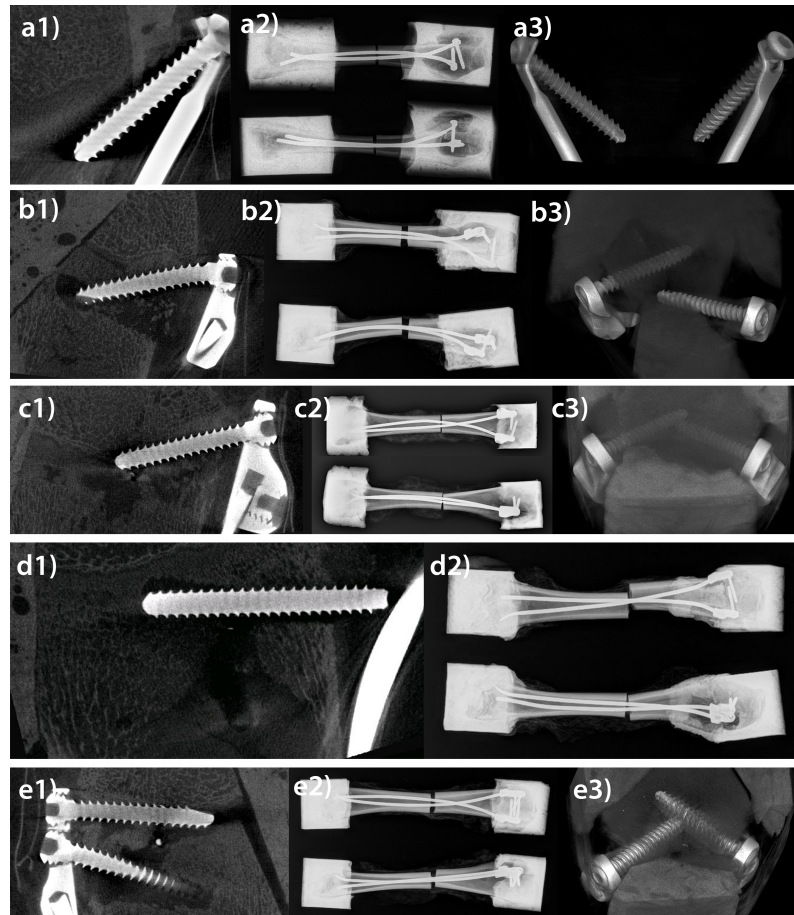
Used interlocking systems Ender nail a), Plug 3.5 b), Fixplug c), Plug 3 d) and Twin plug e) are displayed within this figure.  $\mu$ CT coronal views are displayed in a-e 1), a-e 2) show clinical radiographs, performed at the Department of Paediatric Radiology, Medical University of Graz, a-c 3) and e3) show 3D reconstructions of  $\mu$ CT data.
